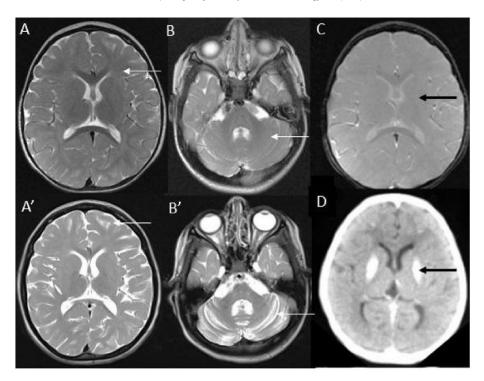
Cockayne Syndrome: T2 axial images at 2 years and 5 years show diffuse hypomyelination (white arrows A -A') with progressive diffuse cerebral and cerebellar (arrows B-B') volume loss. Note homogenous calcifications in putamen bilaterally on CT (Black arrow in D). Note that this is not apparent on gradient MRI sequence (C).
